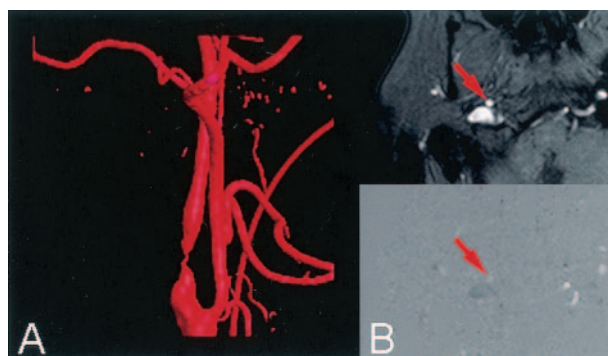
A very high-grade stenosis of the ICA depicted via 3DRA (A). Tight stenoses such as this could not be directly depicted with CE-MRA, although the presence of downstream contrast and measurable flow provide evidence of residual patency. B, Magnitude (top) and phase (bottom) MR images demonstrating the ICA (arrows) just distal to the stenosis, where the phase image reveals small, but nonzero, flow.
